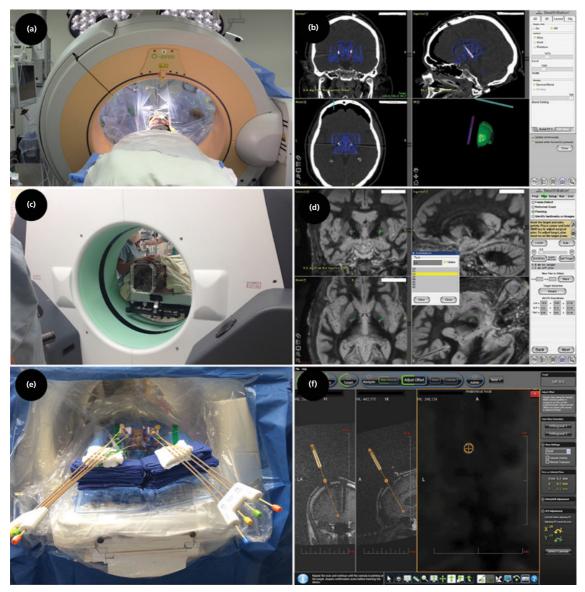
Three-dimensional (3D) radiological control. 3D radiological control is the gold standard for ascertaining final DBS implantation accuracy and is the *best* when it occurs intraoperatively when adjustments can more easily be made than post-operatively (a). Several options are available at present. The O-arm (Medtronic) is a flat-panel cone-beam CT scanner that provides both intraoperative lateral and anterior/posterior fluorography as well as 3D CT scanning (b) (albeit with somewhat less resolution that traditional fan-beam CT). It can be used for determining intraoperative accuracy by co-registration to the pre-operative MRI using the Stealth neuronavigational workstation. Source: a and b are courtesy of K. Holloway, Medical College of Virginia. True fan-beam intraoperative CT scanning is available using the Bodytom (c) or the smaller Ceretom (Samsung Neurologica). The intraoperative CT scans can similarly be co-registered to the pre-operative MRI using neuronavigational software (e.g. Stealth, d). Source: c and d are courtesy of F. Ponce, Barrow Neurological Institute. Surgery can be performed in the MRI suite (e), or in the operating room using an intraoperative MR unit. In this case, DBS insertion is performed after aligning the stereotactic device (e.g. Clearpoint as shown in e and f, MRI Interventions) and checking insertion accuracy with a ceramic stylet inserted through a peel-away sheath. Any inaccuracies are immediately seen on the MRI scan and can be adjusted before closure.
